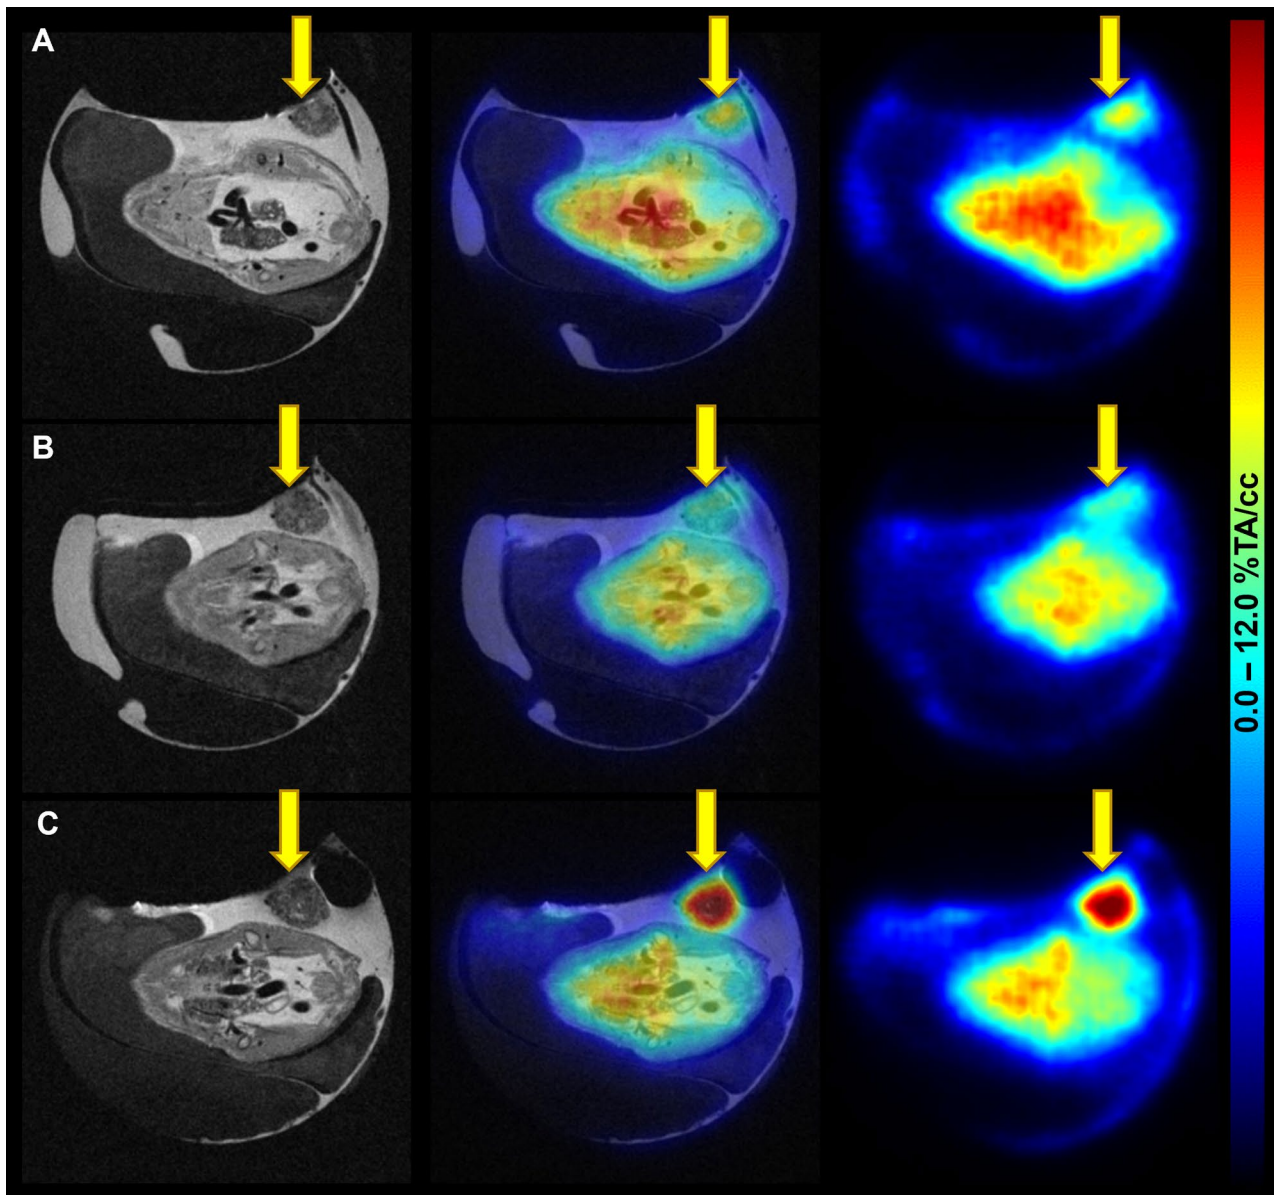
Images of ^{68}Ga]Ga-Pentixafor and 2- ^{18}F]FDG PET/MRI in the CAM-PDX model of CRC. (A) ^{68}Ga]Ga-Pentixafor baseline (EDD16; 4.1 MBq, 1.6 nmol ^{68}Ga]Ga-Pentixafor), (B) blocking (EDD17; 7.2 MBq, 2.3 nmol ^{68}Ga]Ga-Pentixafor; 315 μg AMD3100), and (C) 2- ^{18}F]FDG scans (EDD18; 5.8 MBq) were performed using the same subject on three consecutive days. Left: T_2 -TurboRARE MR images, right: PET images 60 min *p.i.*, middle: fused PET/MR images in axial view. PET data are provided as a percentage of total activity per cm^3 (%TA/cc). The xenograft is marked with yellow arrows
